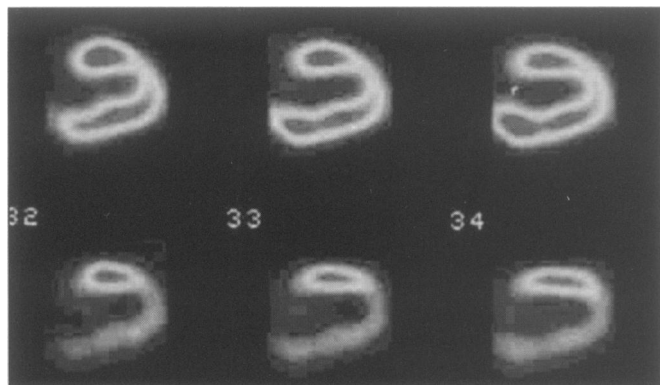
Improvement generated by attenuation correction (AC). Lower row shows vertical long-axis slices of myocardial perfusion rest SPECT without correction, showing a marked inferior defect originally judged to be an infarction. Upper row shows corresponding images after AC, now correctly normal.
